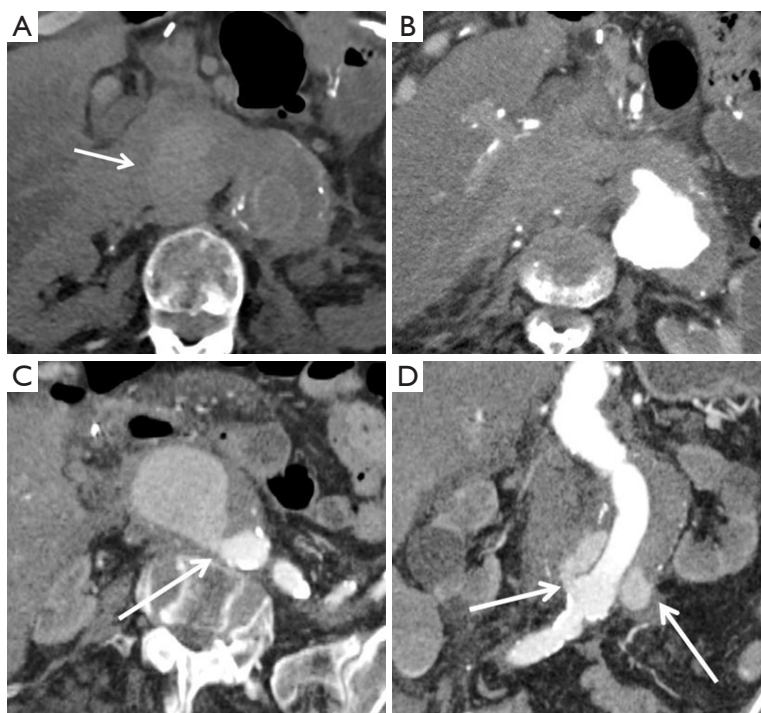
Stent graft dehiscence in a 75-year-old man with history of ruptured abdominal aortic aneurysm following open aortic repair, presented with back pain after open aortic repair. (A) Axial non-contrast CT shows large amount of hyperdense fluid (arrow) at mid retroperitoneal region and moderate amount of hemoperitoneum; (B) axial CT angiogram shows a large abdominal aortic aneurysm; (C) axial and (D) coronal CT angiogram demonstrates extraluminal contrast material (arrows) at right side of the inferior anastomotic site.
